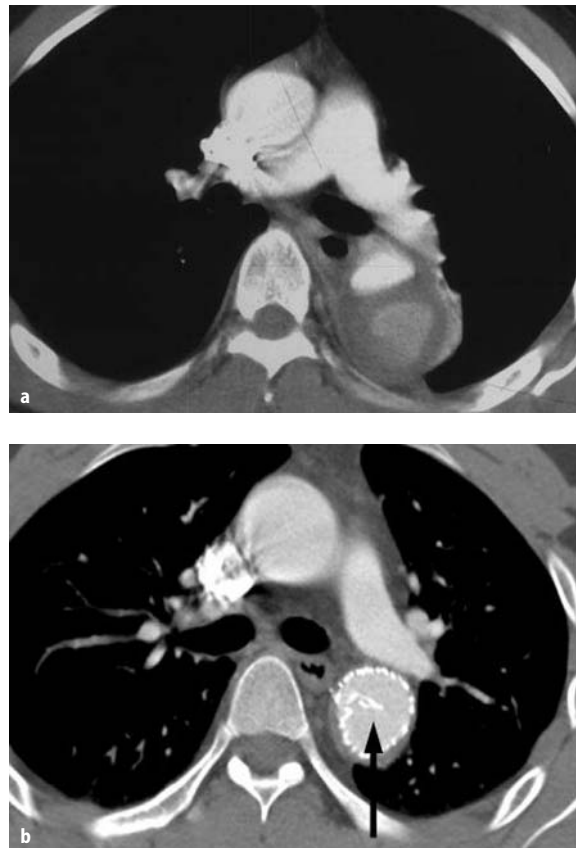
Stent-graft folding. A 56-year-old man with De Bakey type III chronic aortic dissection. a Preoperative computed tomography (CT) scan shows the true lumen and the false lumen of the descending thoracic aorta. b Fifty-two-month follow-up CT scan after the stent-graft treatment. Despite inward folding of the stent-graft strut (arrow), complete resolution of the thoracic false lumen is achieved
